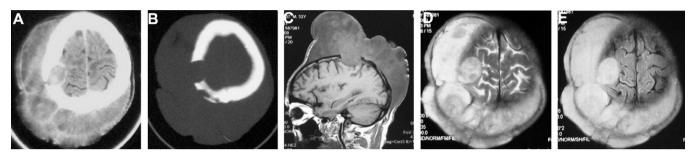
Axial CT scans of the tumor showing: (A) heterogeneous density with (B) partial destruction of the right parietal cranium; and MRI of the tumor showing: (C) heterogeneous hypointensity on T1-weighted sagittal MRI, compared to (D) hyperintensity on T2-weighted axial and (E) fluid-attenuated inversion recovery axial MRI.
